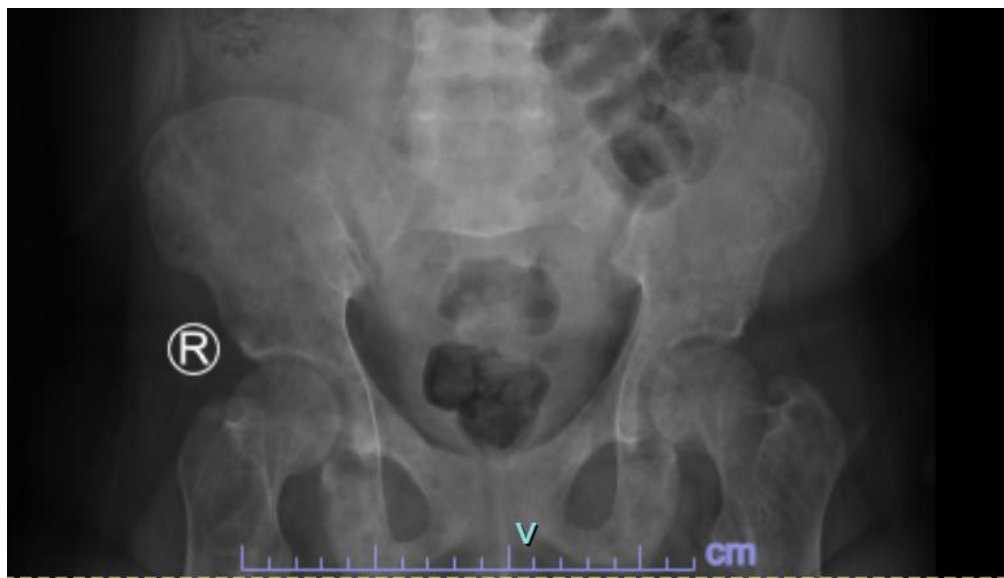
Pelvic x-ray showing multiple lytic lesions in iliac and pubic bones, also both of femoral trochanters
